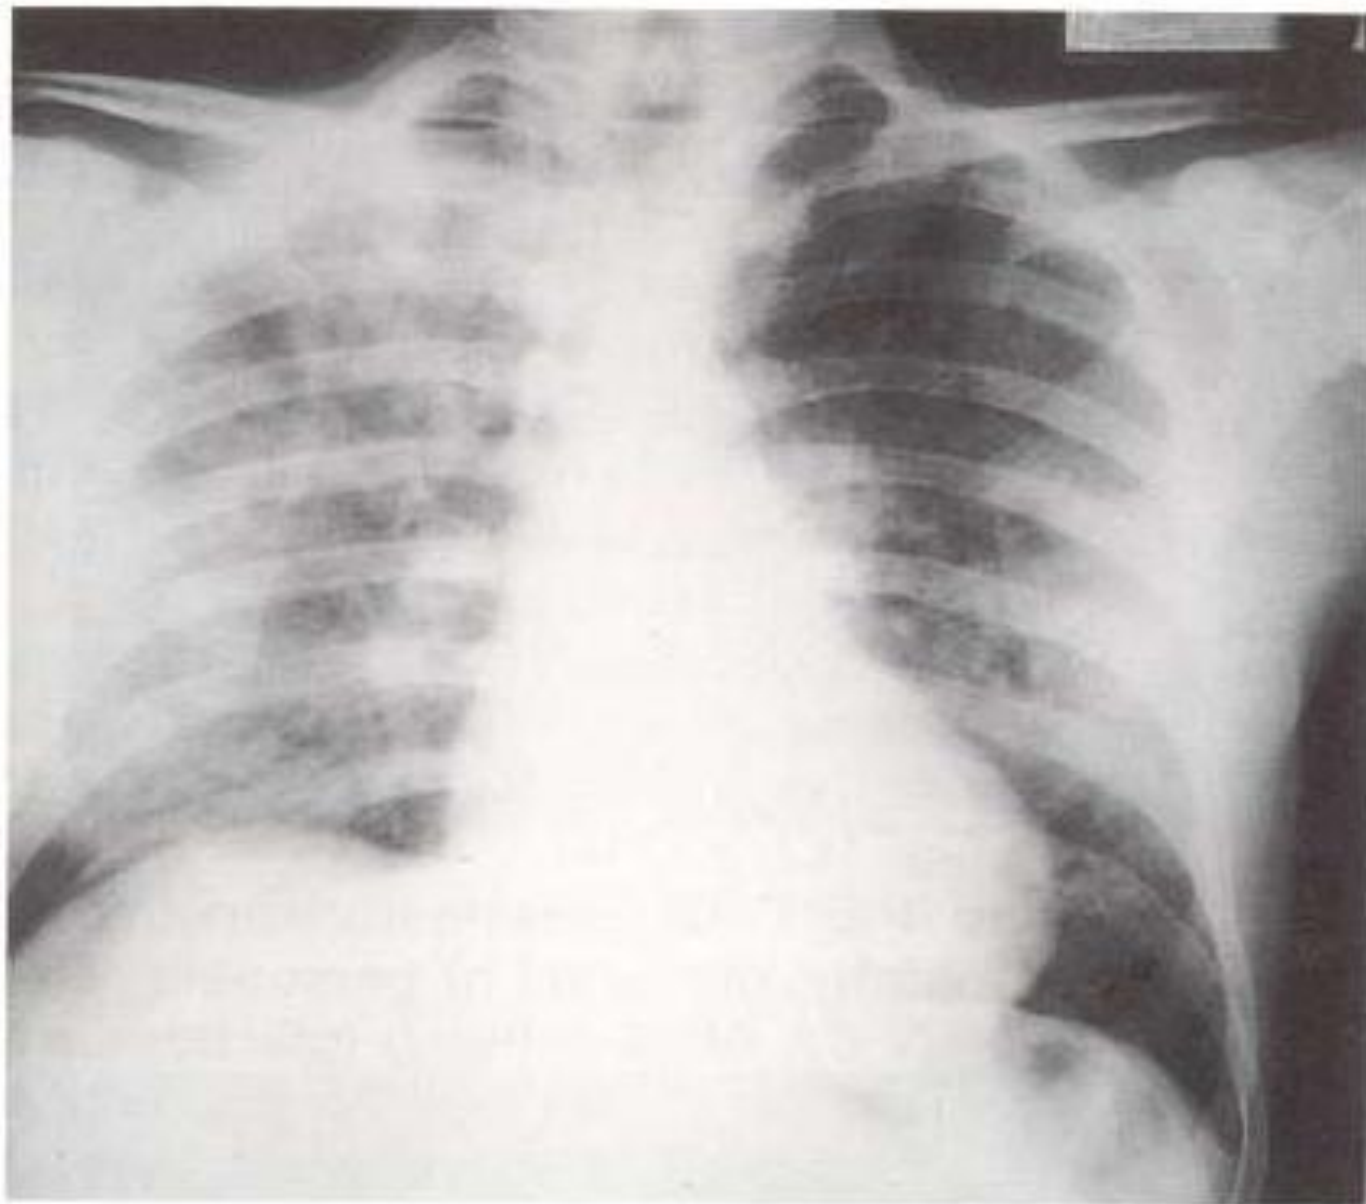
Chest radiograph: *Pneumocystis carinii* pneumonitis.
